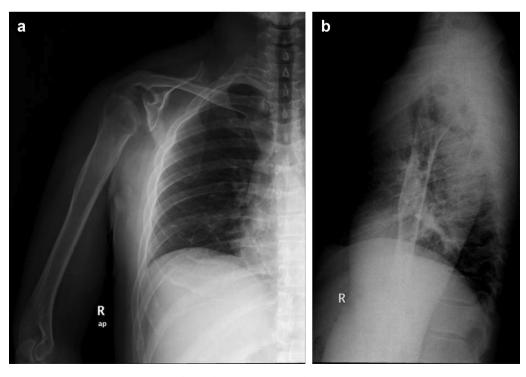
a, b: Pre-operative AP and Lat. X-rays.
